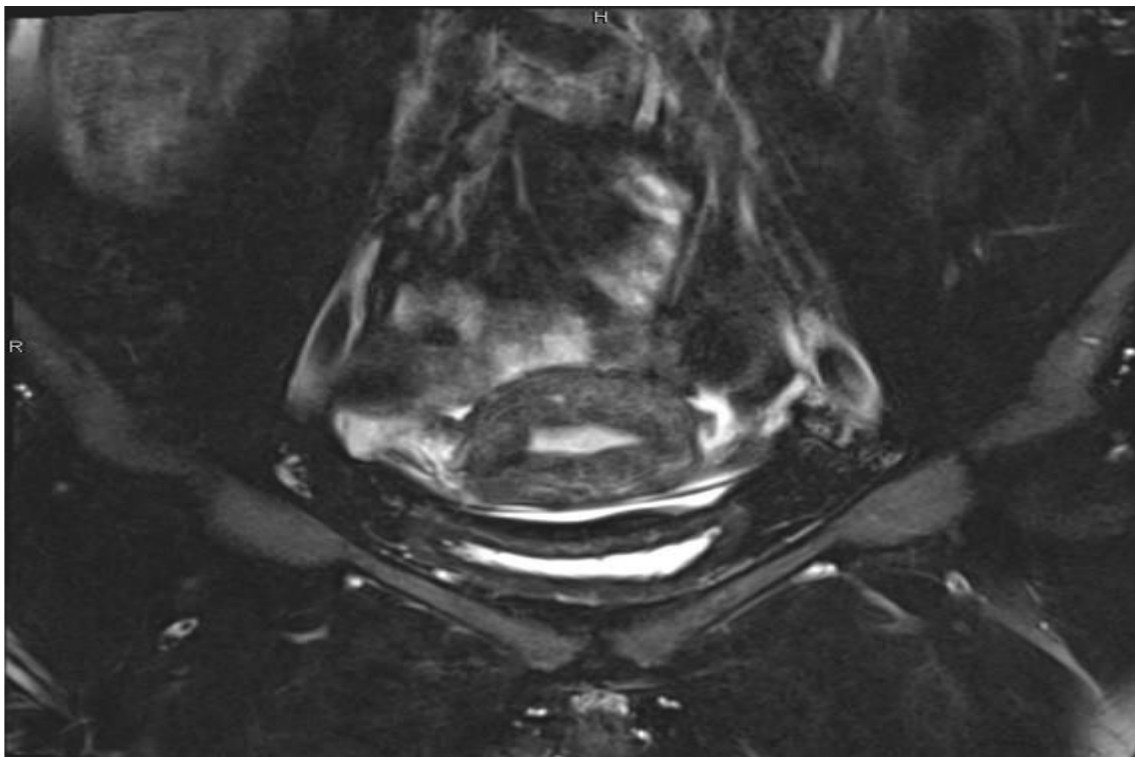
MRI of the pelvis (axial CE-T1weighted and sagittal T2-weighted images) showing a heterogeneously enhanced well-circumscribed hyper vascularized lesion (7.5 x 8 x 6 cm) in the proximal vagina with a stalk-like structure within the uterine cavity. There are no signs of myometrial or parametrial infiltration and there is no evidence of pelvic lymphadenopathy. Vaginal tamponade distant to polypoid mass.
